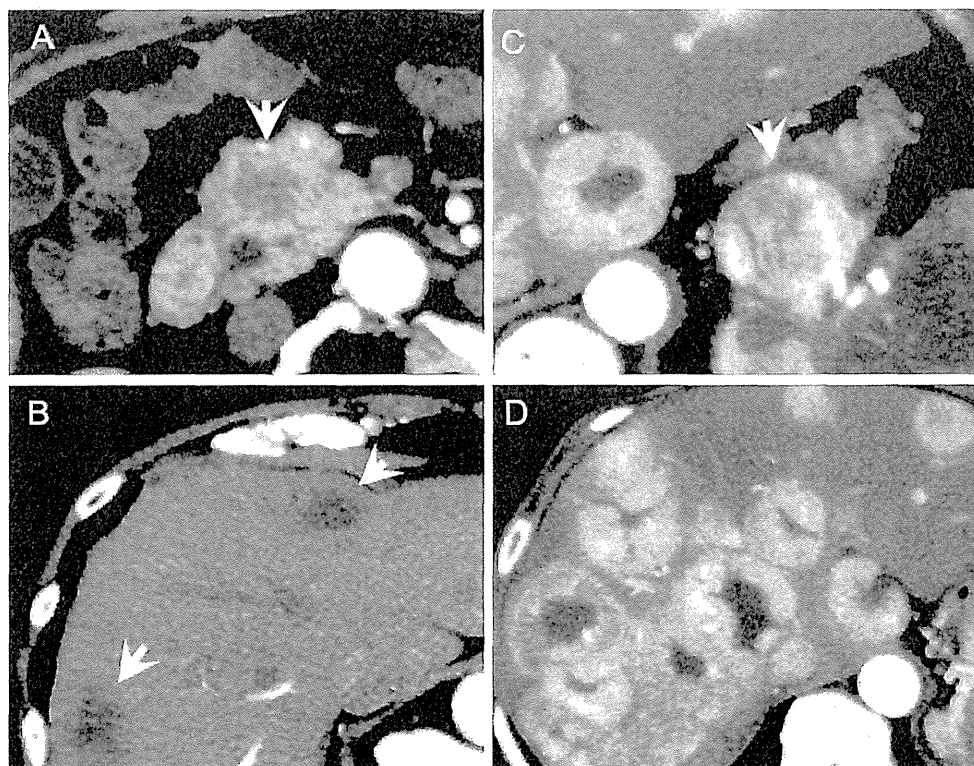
Computed tomography findings of respective pNECs. a, b Hypovascular lesions both primary pancreas head site and multiple liver lesions (SCNEC case). c, d Hypervascular lesions both primary pancreas head site and multiple liver lesions (WDNEC case)
